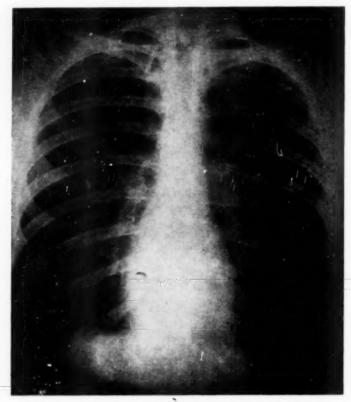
Chest roentgenogram ten days after attack. Lungs are now clear. Heart has decreased markedly in size. (Compare with figure 3.)
